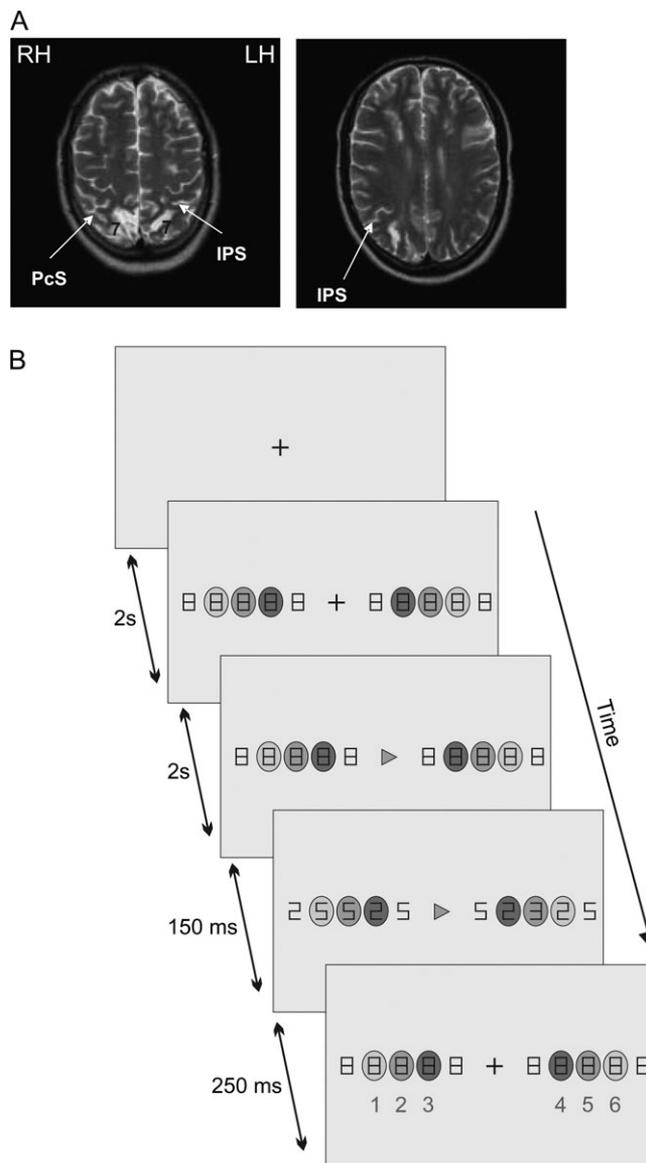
MRI slices of patient CF and task setup. (A) T2 scans for patient CF. The white areas at the bottom of the scans show asymmetrical damage mostly in the right hemisphere in the posterior parietal lobes (area 7 labeled in black). There is also some slight damage in the left premotor cortex. IPS = intraparietal sulcus, PcS = postcentral sulcus. (B) Task setup. Each trial began with the presentation of a central fixation cross. After 2 s, 6 of 10 target locations were presented in different colors on either side of the fixation spot (labeled positions 1–6 as shown in the last panel—these did not appear on the screen during the task). Within each target location, the figure 8 was displayed. After another 2 s, the central fixation cross changed into an arrow indicating the direction of the saccade. Subjects were instructed to always make saccades to the middle circle location (either position 2 or 5). In this case, the arrow indicated to the subjects to make a saccade to the right (position 5). Subjects were instructed to make a saccade as soon as they saw the arrow. After 150 ms, a letter was briefly presented at one of the 3 colored locations (gray ovals) in the direction of the arrow, either an E or \exists , whereas all other locations changed to figures "2" or "5". In this case, the letter was presented at the saccade goal. After another 250 ms, all locations changed back into a figure "8." After the saccade, subjects were required to report whether the letter was an E or an inverted E by a forced-choice button press.
